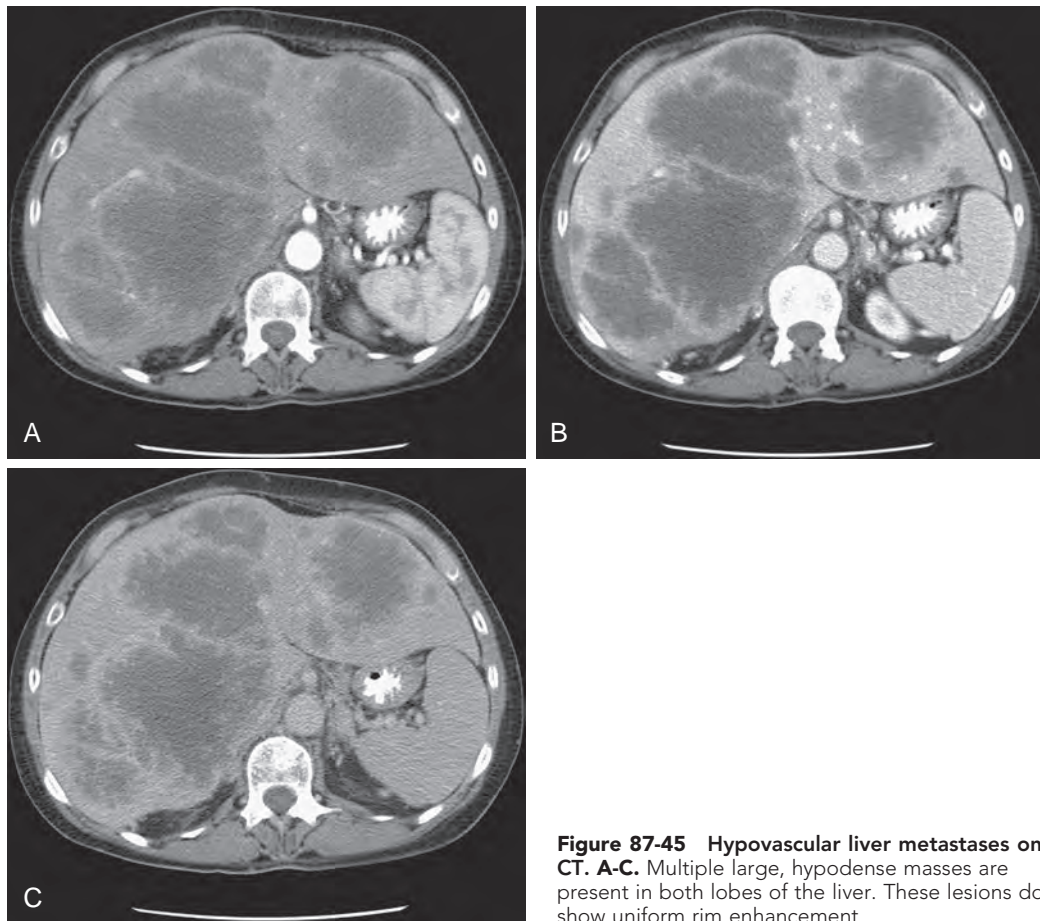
Hypovascular liver metastases on CT. A-C. Multiple large, hypodense masses are present in both lobes of the liver. These lesions do show uniform rim enhancement.
